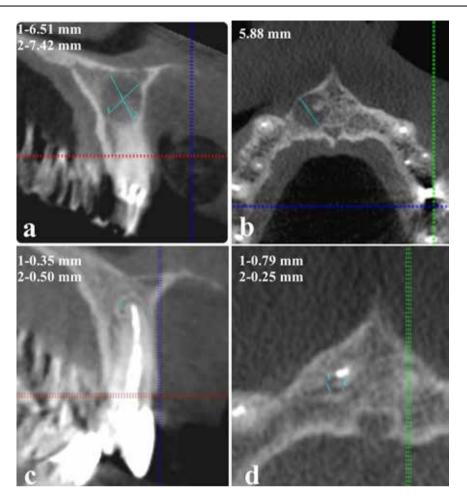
Cone-beam tomography scans, tooth 11: (a) big periapical lesion in sagittal plane, during the treatment; (b) big periapical lesion in axial plane, during the treatment; (c) small periapical lesion in sagittal plane, at one-year follow-up; (d) small periapical lesion in axial plane, at one-year follow-up.
